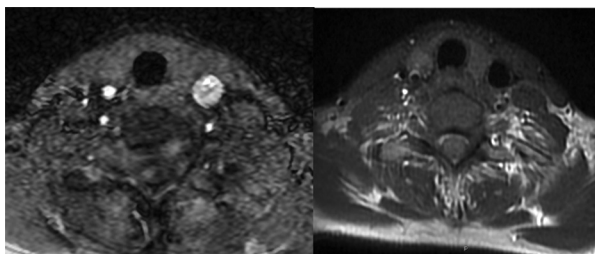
MR was performed with additional T1W fat/sat MRI sequence in order to evaluate the presence of intimal hematoma in the blood vessel wall known as 'crescent sign', which is seen in acute arterial wall dissection. This sign was absent.
